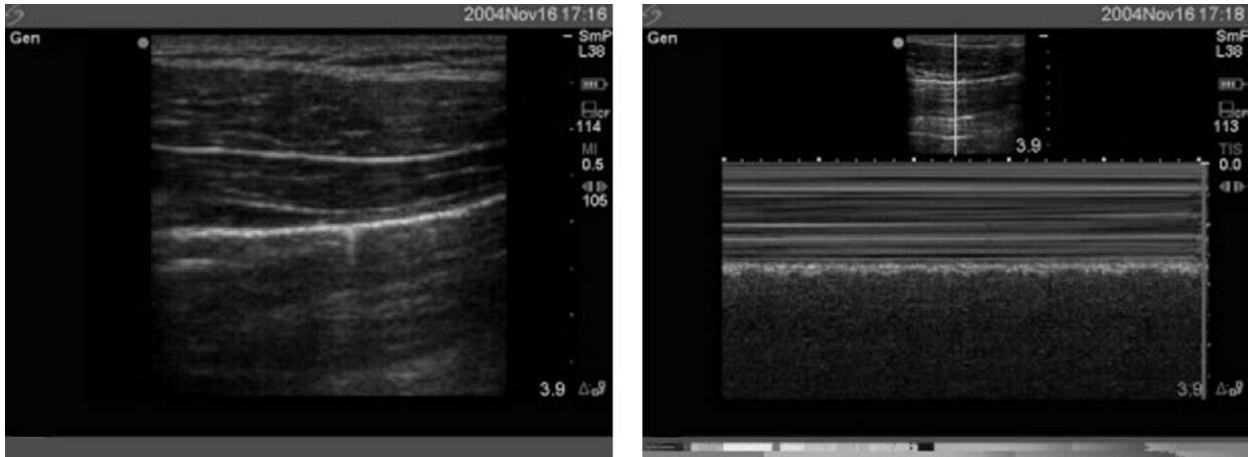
(a) Standard 2D ultrasound image: bedside ultrasound demonstrating the ‘comet tailing’ phenomenon and the ‘sliding sign’ (see video) consistent with the ultrasound findings described when *no* pneumothorax is present. (b) M mode ultrasound: (motion is demonstrated by granularity, lack of motion appears as a series of horizontal lines). Below the pleural line there is homogenous granularity typical of normal lung and pleura (no pneumothorax).
